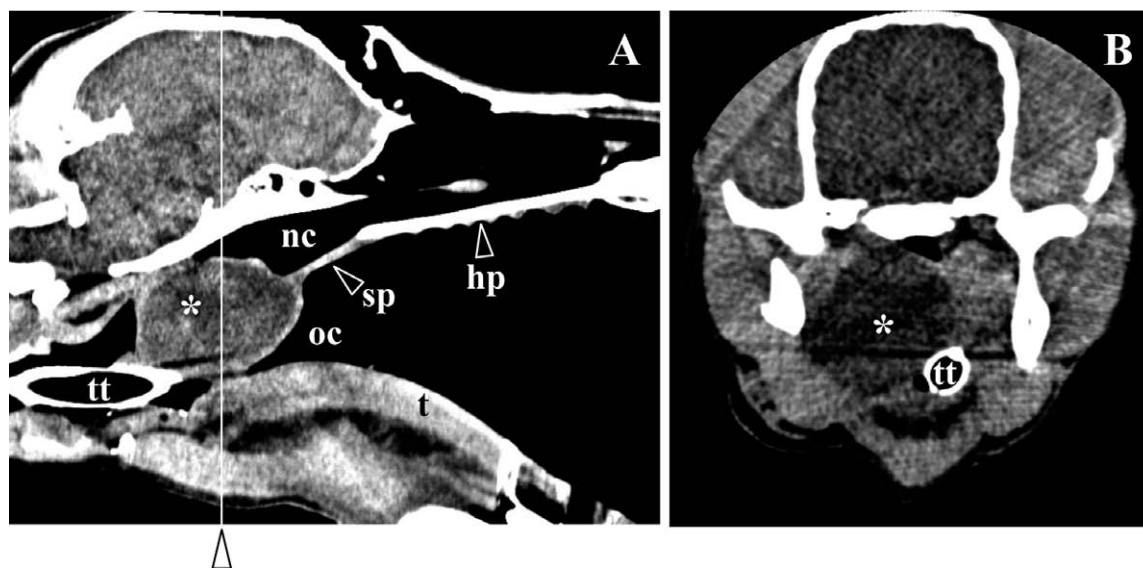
CT photograph at 1st admission (A and B: sagittal multiplanar reconstruction CT image and an axial section at A- $\Delta$ , respectively). Spherical cystic radiolucency (\*) inside the soft palate (sp) behind the hard palate (hp) is recognized. This radiolucency (\*) contacts the tongue (t), and the nasal cavity (nc) and oral cavity (oc) are blocked off. There is little space for tracheal tube (tt) entry.
